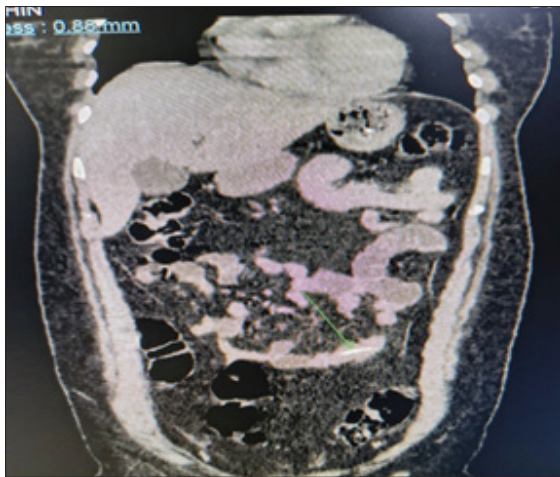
A & 4 B: CT abdomen showing Fish bone inside the small bowel lumen
